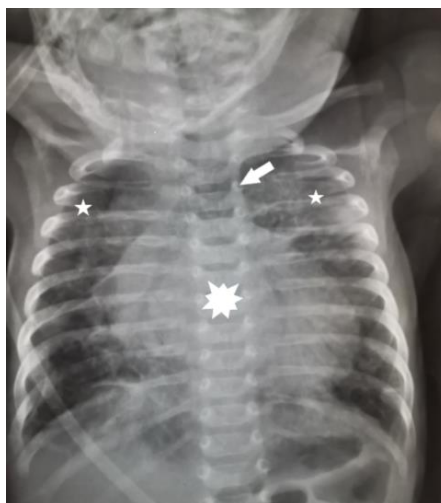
Chest radiograph: Cardiomegaly with an “egg-on-its-side” appearance (multipointed star), vascular congestion predominating in the parahilar regions and bilateral upper lobes (stars). Thymic hypoplasia with a narrow superior mediastinum (arrow).
